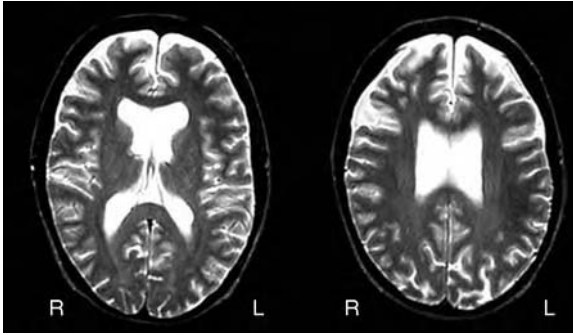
This axial T2 weighted magnetic resonance imaging (MRI) obtained at the age of 22, of an individual with early adolescent onset schizophrenia demonstrates prominence of the ventricular system as well as cortical cerebral spinal fluid (CSF), representing significant cerebral atrophy, easily appreciated when compared to the normal axial image at a similar level shown in Figure 19.1b. Also, note that the atrophic changes are more apparent in the frontal areas in contrast to posterior.
